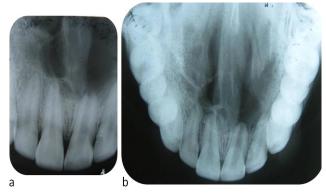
Preoperative IOPA in relation to 11 & 21, b) Occlusal view radiograph of the maxilla.
